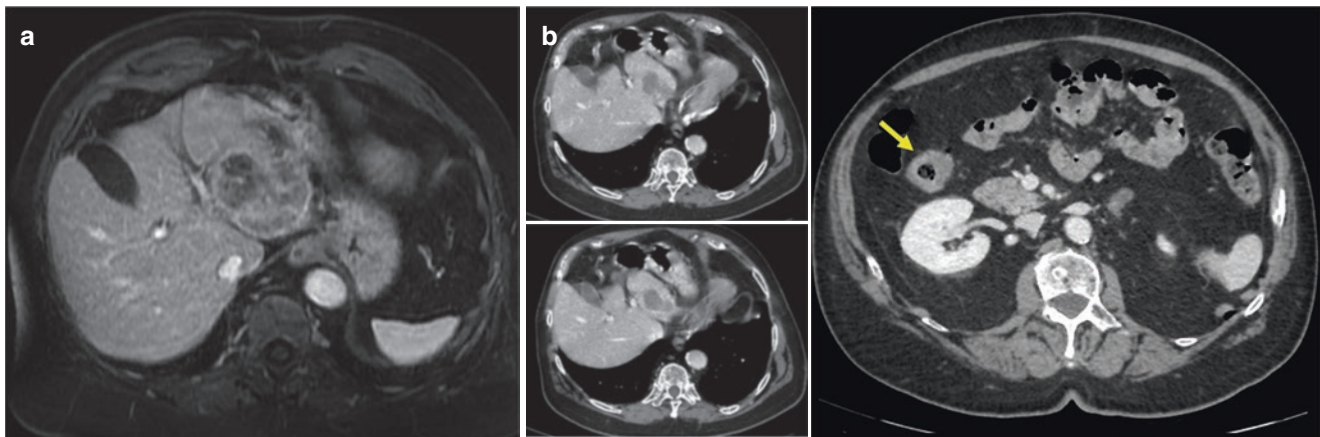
Low-risk colorectal resection and major hepatectomy: a 64-year-old male patient. Preoperative CT scan showing a right colon cancer (yellow arrow) with synchronous large CRLM of the right
